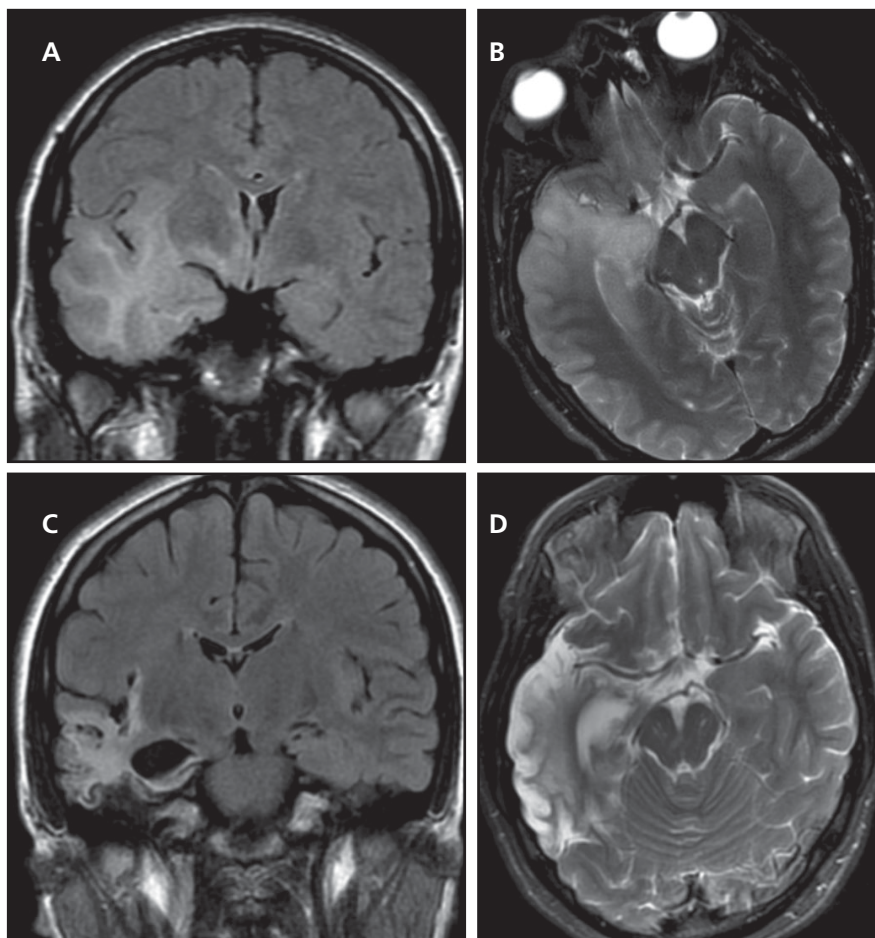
Herpes simplex encephalitis (HSE). Coronal FLAIR (A) and axial T2 (B) images demonstrate abnormal hyperintense signal involving the right insula, temporal lobe, and inferomedial frontal lobe with associated mass effect. Repeat coronal FLAIR (C) and axial T2 (D) images 4 months later following treatment with acyclovir demonstrates corresponding areas of encephalomalacia and gliosis with parenchymal volume loss, reflecting the chronic sequelae of HSE.
